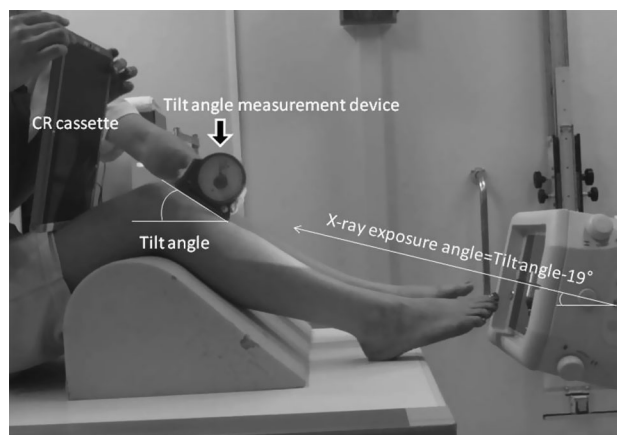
Clinical image of measurements obtained with an inclinometer. Imaging involved maintaining 60° knee flexion and with use of an inclinometer to set the incident X-ray angle at 19° to the reference line connecting the anterior border of the patella and the tibial tuberosity
